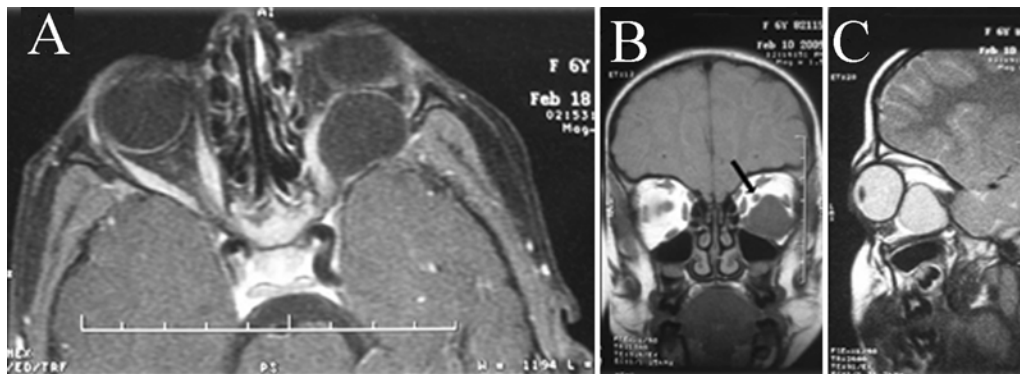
Preoperative MR imaging of the patient. A: Axial T1-weighted image of the left orbita with Gd injection demonstrating globe deformation and proptosis of the orbit due to a retroorbital huge cystic lesion with fine peripheral rim enhancement. B: Coronal T1-weighted image showing an inferolaterally localized cystic lesion with low signal intensity displacing the optic nerve superomedially (arrow). C: Sagittal T2-weighted image showing a cystic lesion with high signal intensity displacing the globe anteriorly.
